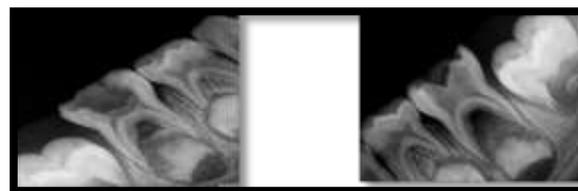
IOPA radiograph in relation to 85 and 75
